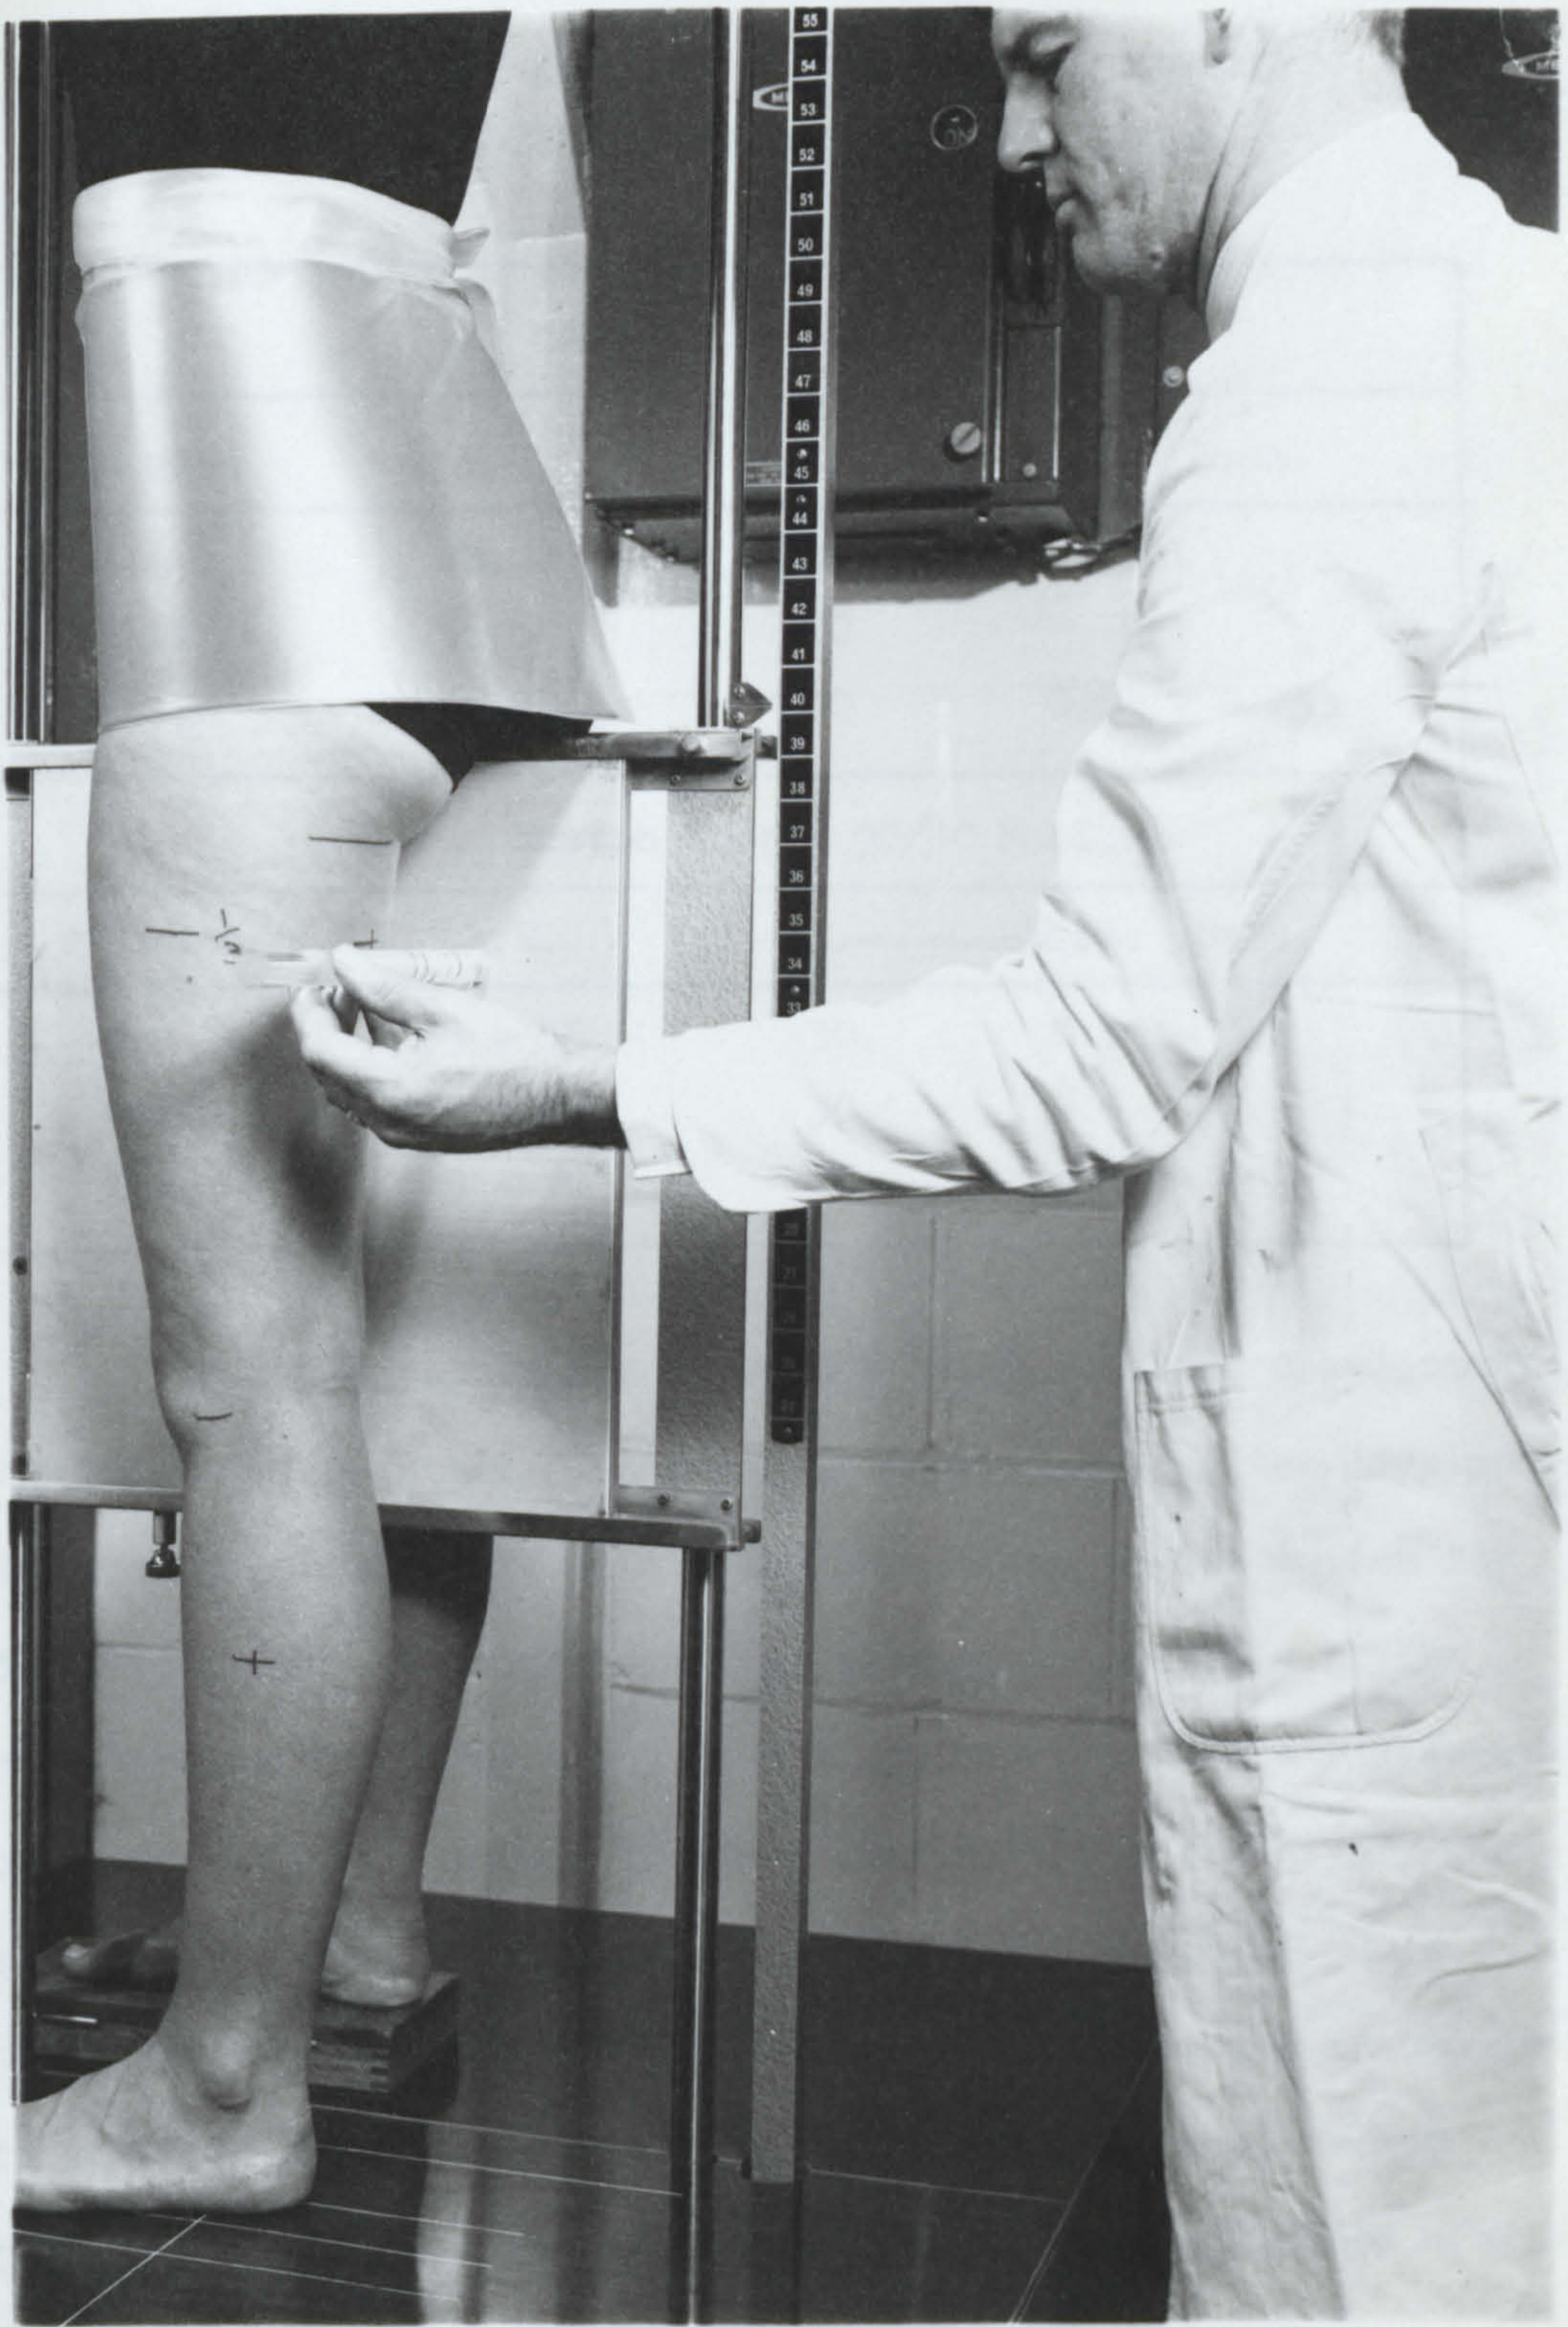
Roentgenogrammetric pose for the thigh area.
